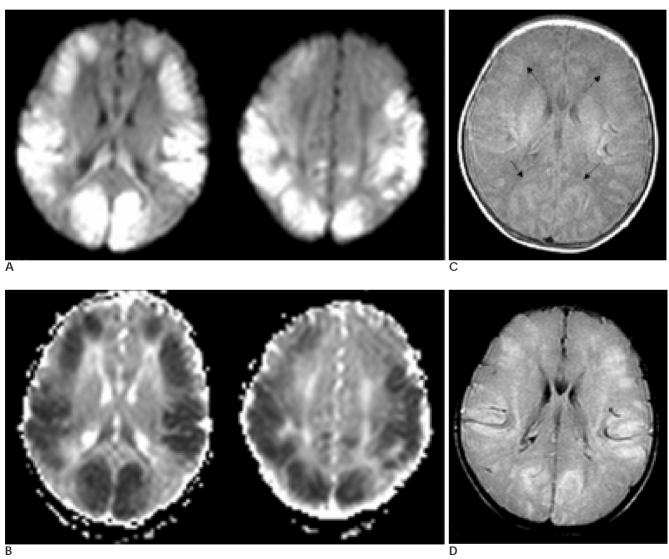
MR images on 2 days after the onset of neonatal hypoglycemia.
